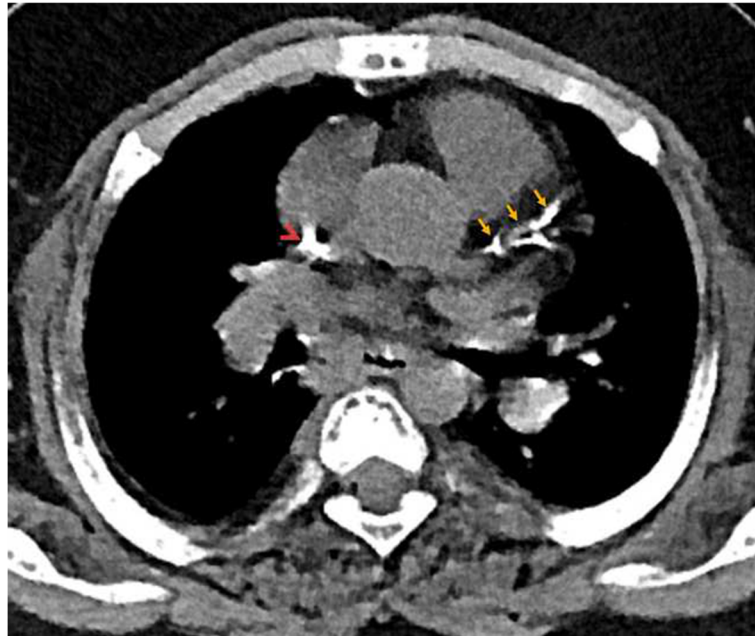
In the contrast-enhanced chest CT image obtained 1 year ago, the persistence of the chronic calcified thrombus (arrowhead) in the superior vena cava and newly formed calcific atherosclerotic plaques are observed in the left anterior descending (LAD) coronary artery (arrows)
